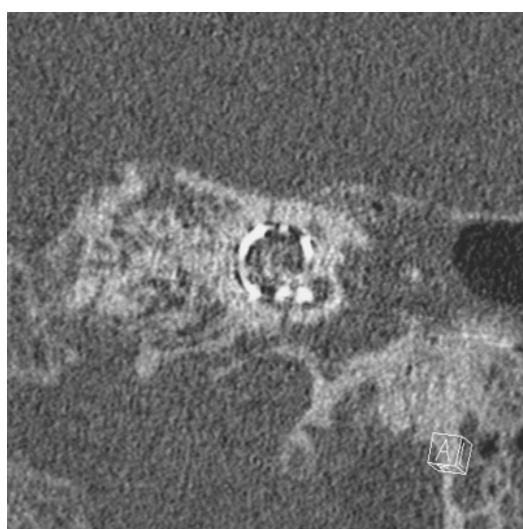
Postoperative CT scan demonstrating correct intracochlear positioning of the electrode array.
